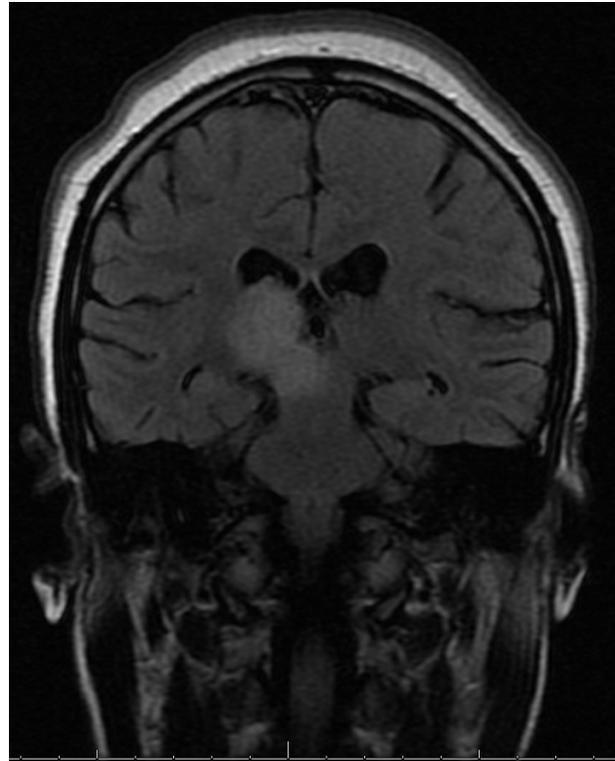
Thalamic and hypothalamic T2/FLAIR hyperintense signals.
